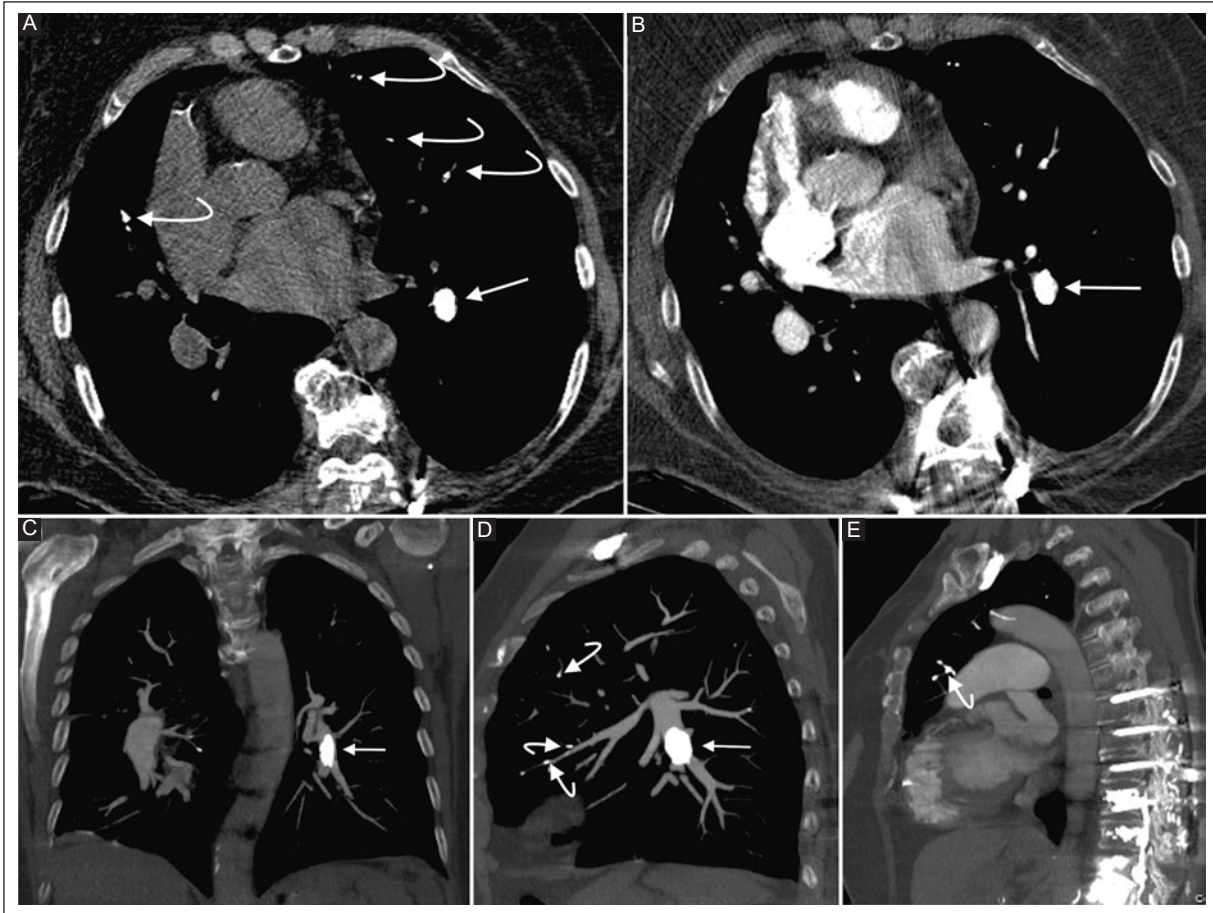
An 88-year-old female patient with a history of vertebroplasty and fixation with osteosynthesis of the dorsolumbar spine. A: non-enhanced chest CT, axial image. B: CTPA, axial image. C: coronal reconstruction. D-E: sagittal reconstruction. A hyperdense image is observed occupying the entire pulmonary artery lumen of the left lower lobe (arrow) and some additional images in subsegmental branches in the middle lobe and lingula (curved arrow). Post-surgical changes of the dorsal spine with osteosynthesis material and vertebroplasty changes with hyperdense material in the vertebral bodies and some lumbar veins.
